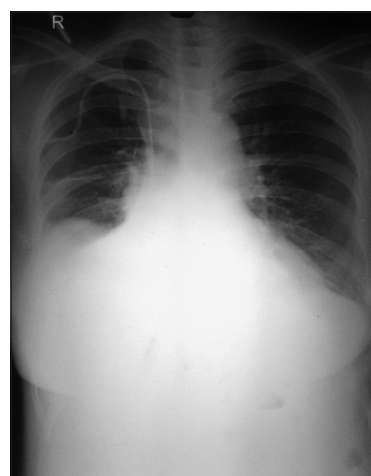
Chest X-ray 3 days after conversion to sirolimus
